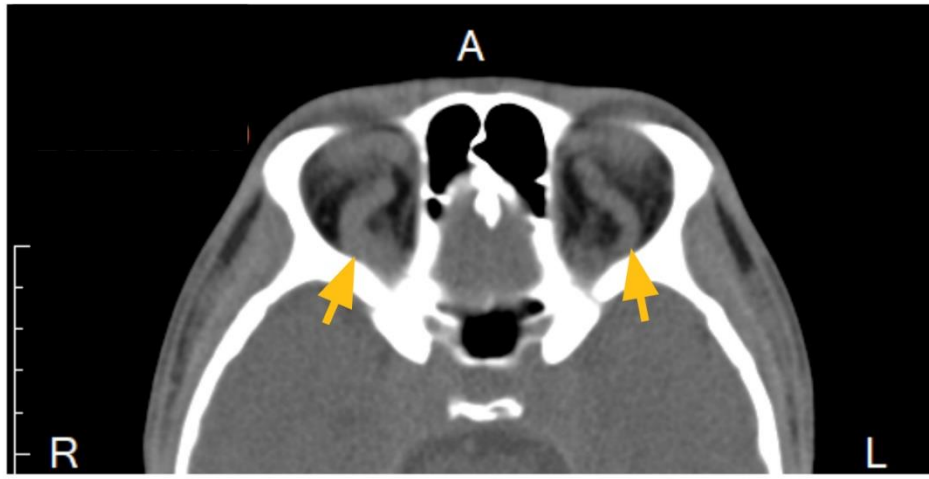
Computed tomography showed bilateral engorged superior ophthalmic veins (SOVs)
